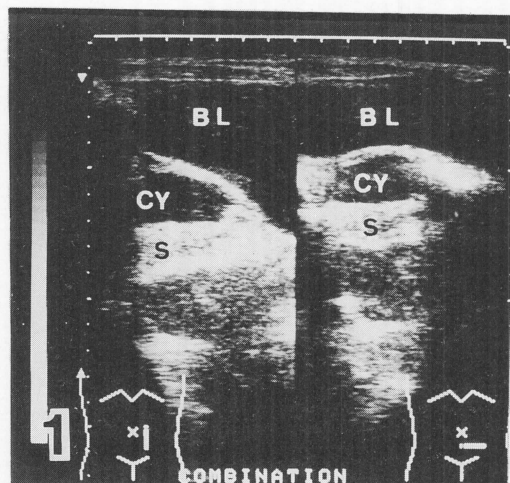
Ultrasonogram. Longitudinal (left) and transverse (right) scans of the left ovarian tumor show a mixed pattern. (S: solid part, Cy: cystic part, BL: bladder)
